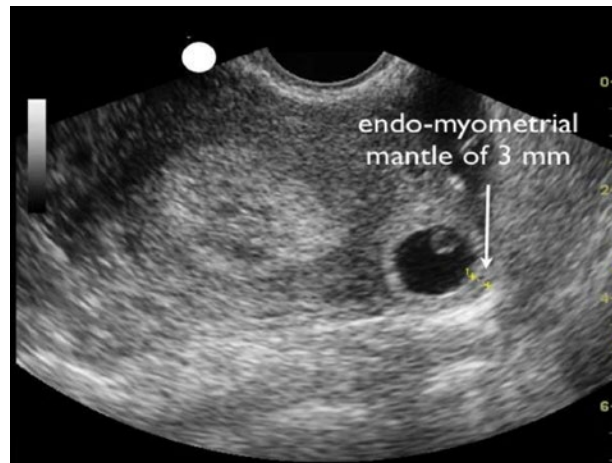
[Ultrasound image showing an interstitial \(cornual\) ectopic pregnancy.](#)
